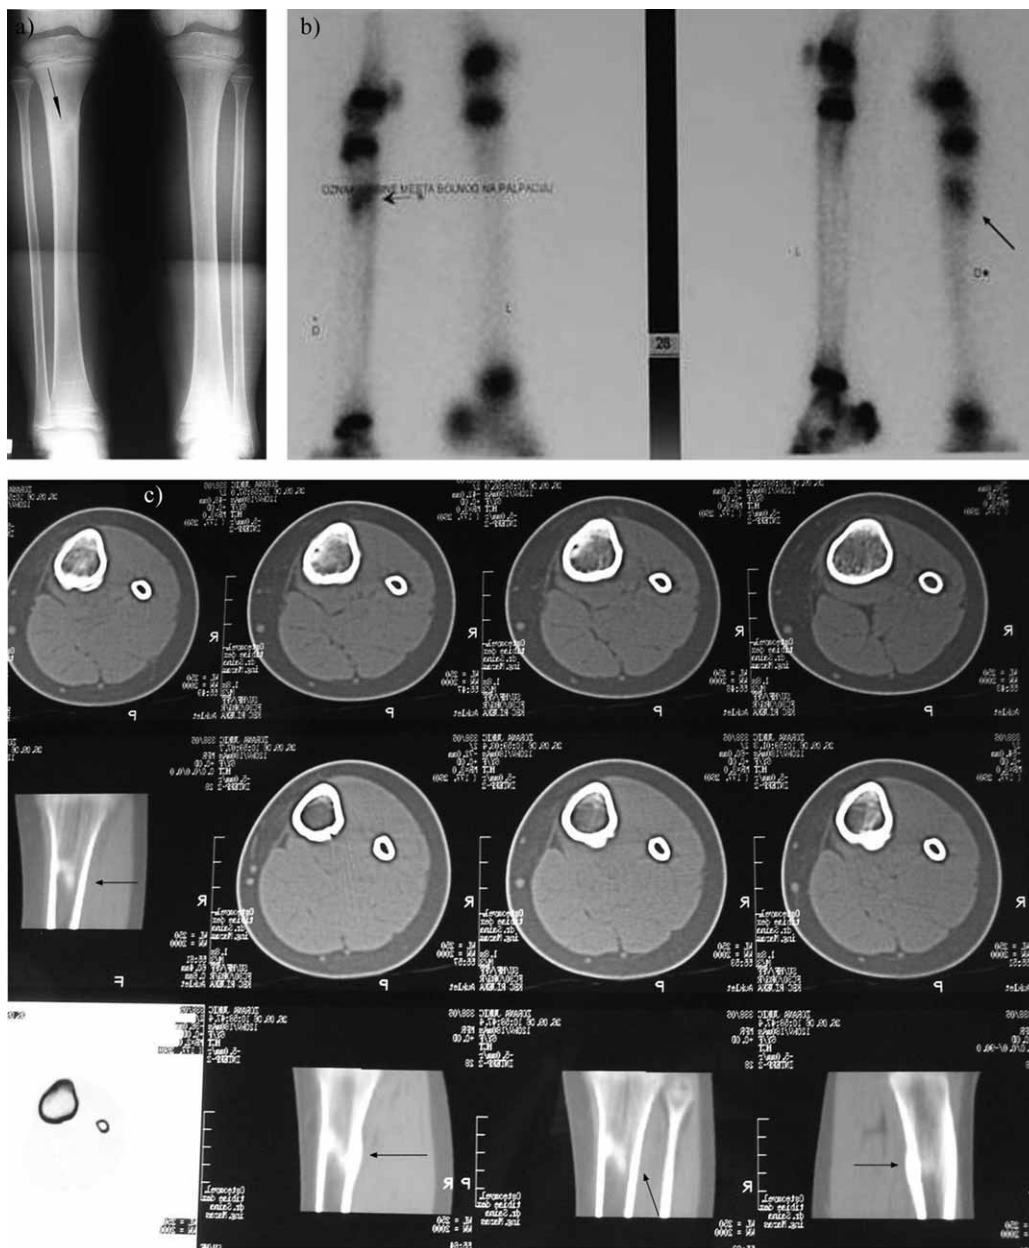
a) The control radiographs, b) bone scan, and c) CT showing stress fracture (black arrows) at the proximal part of diaphysis of the right tibia.
